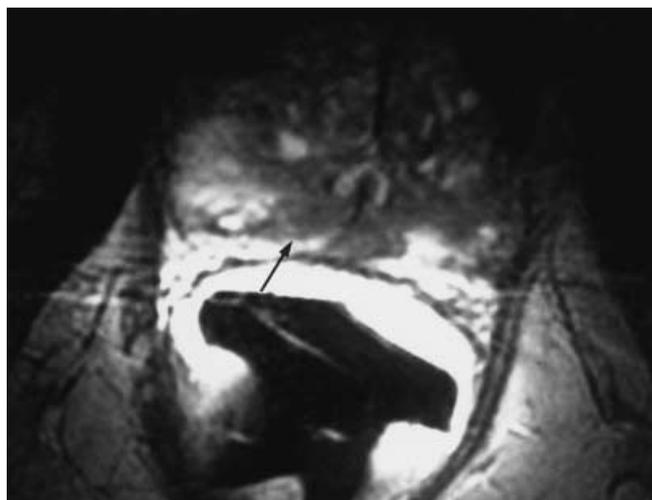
Prostatic carcinoma. Axial T2-weighted image in an 84-year-old patient with PSA levels progressively higher during the past 10 years (6–11–20 ng/ml). A prostate biopsy performed 15 months previously was negative for neoplasia. Endorectal MR imaging shows a low-signal-intensity lesion (arrow) in the peripheral gland indicating tumor. The biopsy guided to the lesion showed adenocarcinoma
